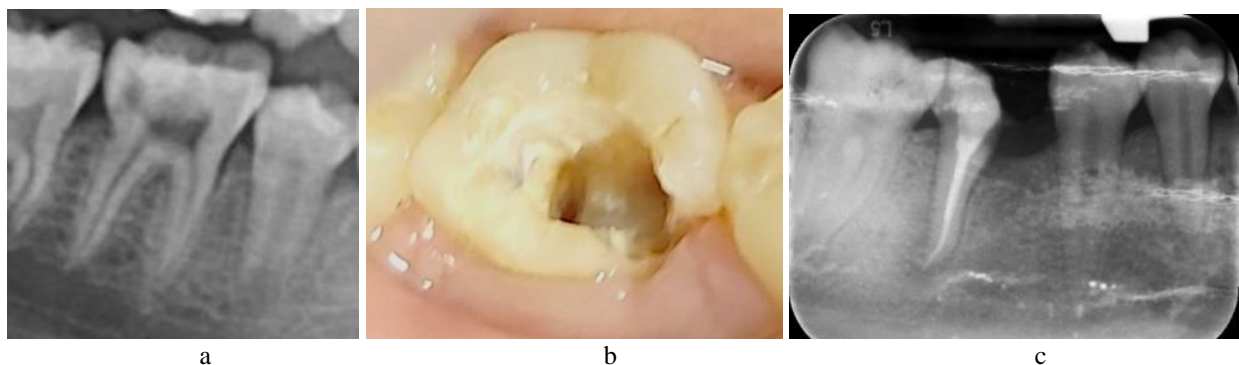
A case of mesial root resection of tooth 46 with fracture on the mesial root. Root filling done. a. previous radiograph before RCT. b. Clinical radiograph showing the fracture in the mesial root. c. After root resection and root filling d. Clinical view after resection of the mesial half of tooth 46. e. Clinical view of the resected root/crown segment.
